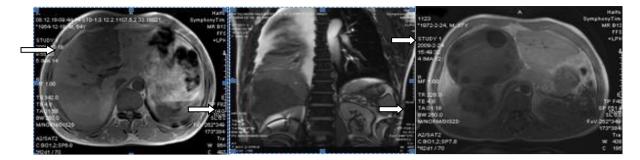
MRI before HIFU treatment (a) A hepatic hydatid cyst (arrow) in patient 1 with a clear boundary and mixed signal intensity within the cyst, (b) Coronal plane with a hepatic hydatid cyst (arrow) with a clear boundary and a mixed signal intensity within the cyst, and (c) a large cyst with a clear boundary in patient 3 (top arrow). Cysts with septations, and of various sizes and strength signal intensity within small vesicles, are seen. The bottom arrow indicates small vesicles within a cyst.
